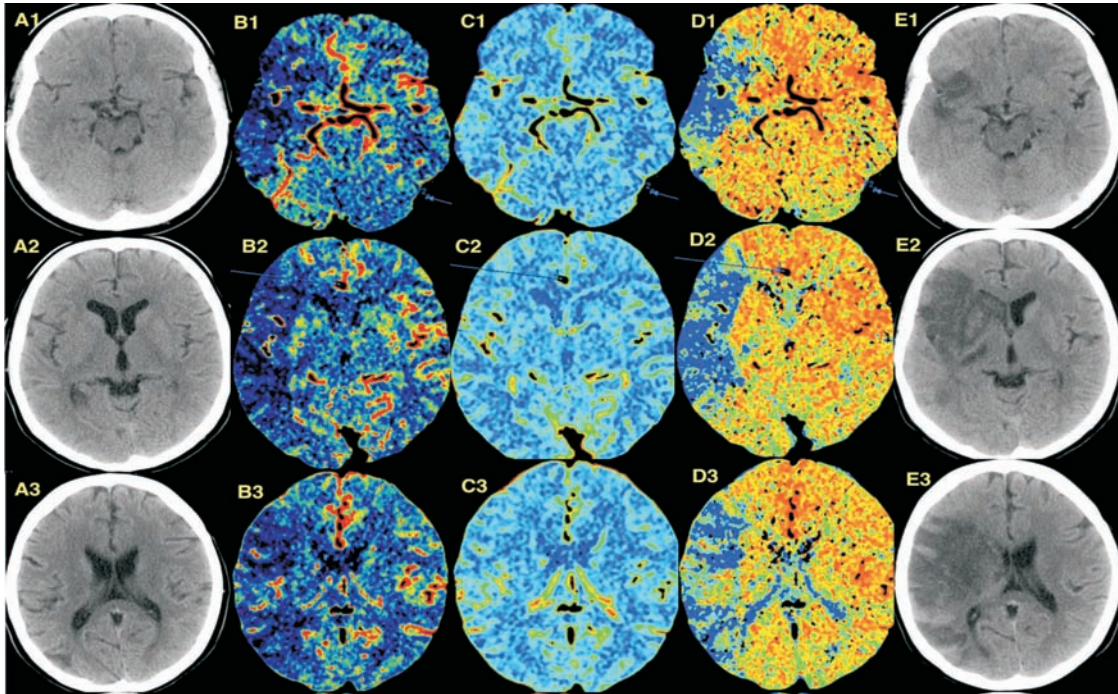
Female patient, 40 years old with known history of arterial hypertension (grade III) and diabetes type 2, presented in emergency department of INN with left hemiparesis. A1, 2, 3 – non contrast CT, 2 hours after symptoms onset – there are no signs of abnormalities. B, C, D – PCT investigation (2 hours after symptoms onset). An extensive area of cerebral hypoperfusion in the right middle cerebral artery vascularization territory. B1, 2, 3 – rCBF map. C1, 2, 3 – rCBV map. D1, 2, 3 – MTT map. E1, 2, 3 – non contrast CT follow-up investigation on 4th day after symptoms onset. An extensive area of cerebral ischemic infarction in the right middle cerebral artery vascularization territory, diffuse right hemisphere edema with compression of the right lateral ventricle.
